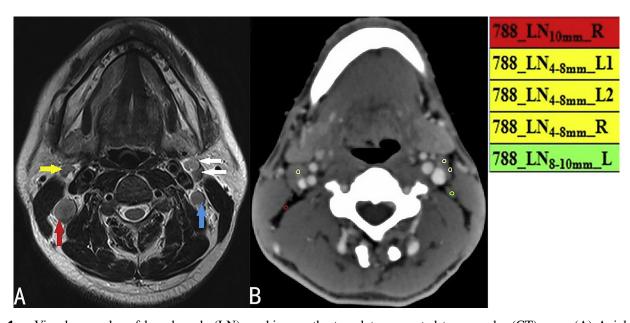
Visual examples of lymph node (LN) marking on the template computed tomography (CT) scan. (A) Axial T2-weighted magnetic resonance images of a 35-year-old man showing 5 LNs in bilateral level II. The left level IIa nodes are 7×10 mm and 6×6 mm (white arrows), the left level IIb node is 9×10 mm (blue arrow), the right level IIa node is 6×9 mm (yellow arrow), and the right level IIb node is 14×15 mm (red arrow). (B) Template computed tomography scan at equivalent axial slice, 3-mm circles represent the center point of emerged LNs. The names of marked LNs consist of 3 parts connected using underscores, for example, in " $788_LN_{4-8mm}_L1$," 788 is the patient number in the cohort, LN_{4-8mm} indicates the minimal axial diameter of this LN is 4 to 8 mm, and L1 indicates that this is the first LN defined in the left side of the neck.
